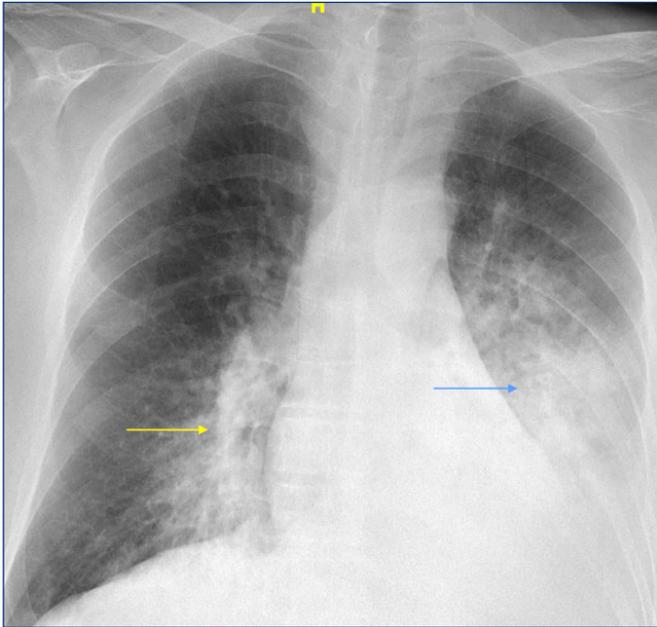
Chest X-ray obtained hospital day one demonstrating opacification of the left lower lobe and blunting of the left costophrenic angle (indicated by the blue arrow), and prominence of the right lobe vasculature (indicated by the yellow arrow).
